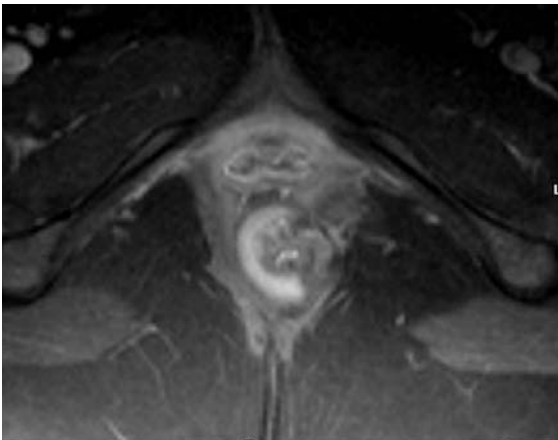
Axial T2-weighted image with fat saturation. Grade 2 horseshoe perianal fistula
